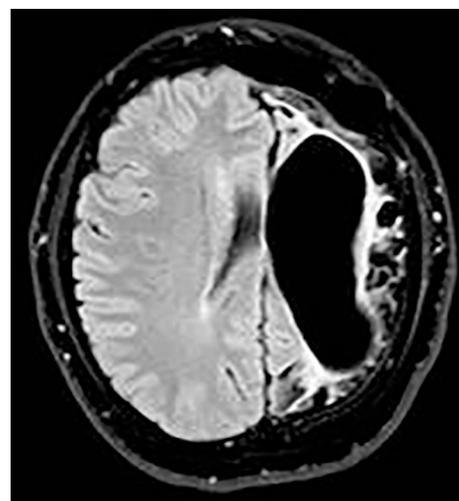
A 20-year-old female patient with left cerebral hemiatrophy and dilatation in compensatory lateral ventricles. Also, extensive encephalomalacia areas in the parenchyma and hyperaeration in the frontal sinuses (MRI Flair).
